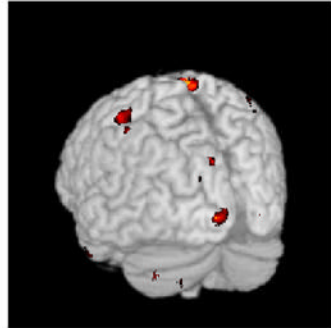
1C. Hemispheric and horizontal renderings from MRI template of significant increases of rCBF between 2.9 Hz and 0 Hz (dark condition), 7.8 Hz and 0 Hz, and 7.8 Hz and 2.9 Hz flash stimulation
